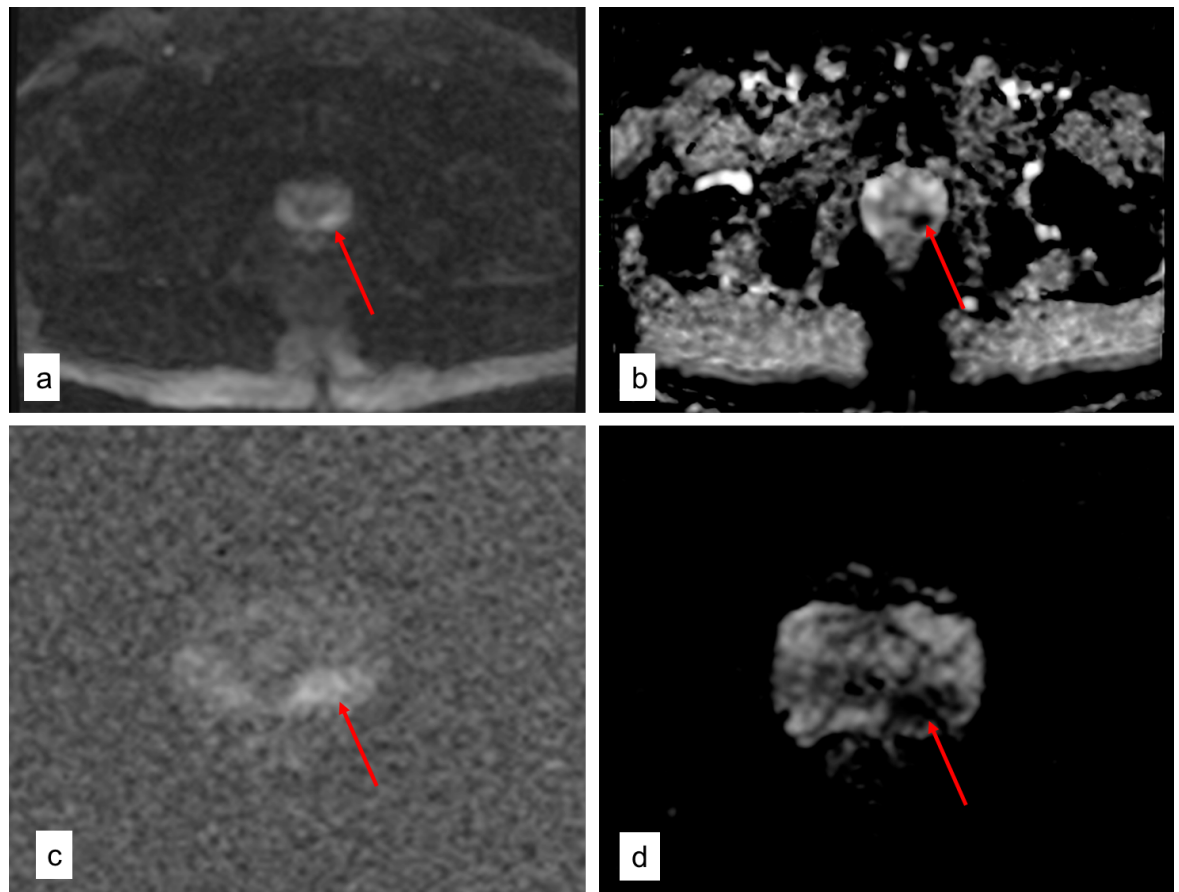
Example of the same left peripheral zone prostate tumour on different DWI sequences and their respective ADC maps. On the DWI images the tumour appears as high signal relative to surrounding non-tumour tissue and on ADC maps the tumour is lower signal than non-tumour tissue. The same Gleason Score 4+3=7 tumour is demonstrated on a) b1500 cDWI. b)ADC map cDWI. c) b1500 sDWI. d) ADC map sDWI.
